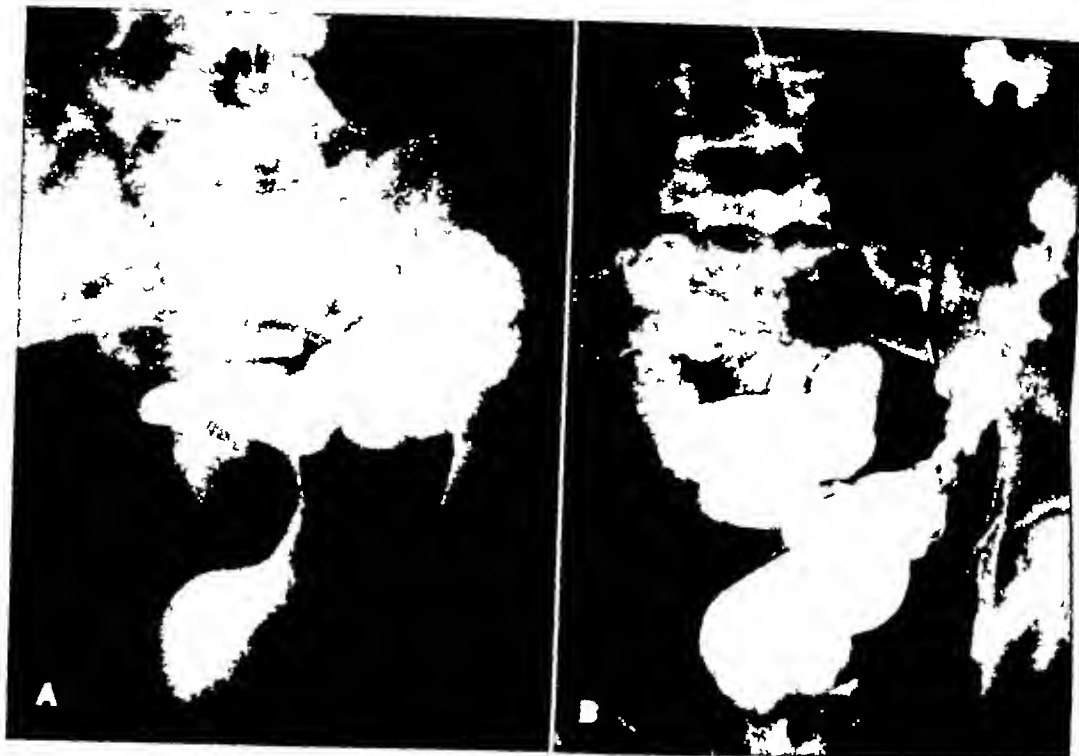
Case VII Involvement of the rectum secondary to carcinoma of the cervix. Views made on March 28 (A) and May 15 (B) before and after roentgen therapy, respectively
